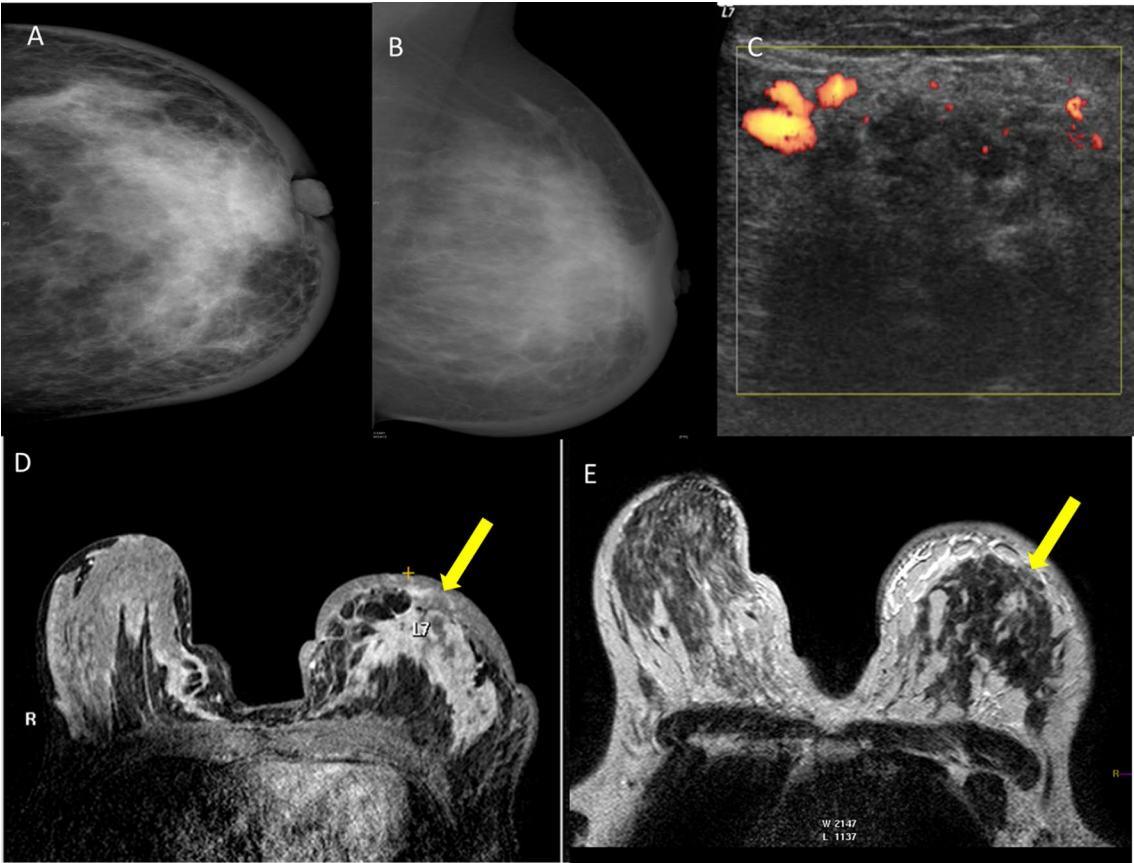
A 35-year-old female with left indurated tender breast, pathology revealed invasive lobular carcinoma. A, B FFDM CC and MLO views show dense breast with diffuse skin thickening and coarsened trabeculae. C Ultrasound findings were equivocal with just increased parenchymal vascularity. D Axial post-contrast dynamic MRI series shows left breast suspicious intense heterogeneous non-mass enhancement extending to the nipple/areola complex (true positive). E Axial T2-weighted MRI image shows corresponding regional area of low signal intensity (true positive) FFDM; full-field digital mammography; CC, craniocaudal view; MLO, mediolateral oblique view.
